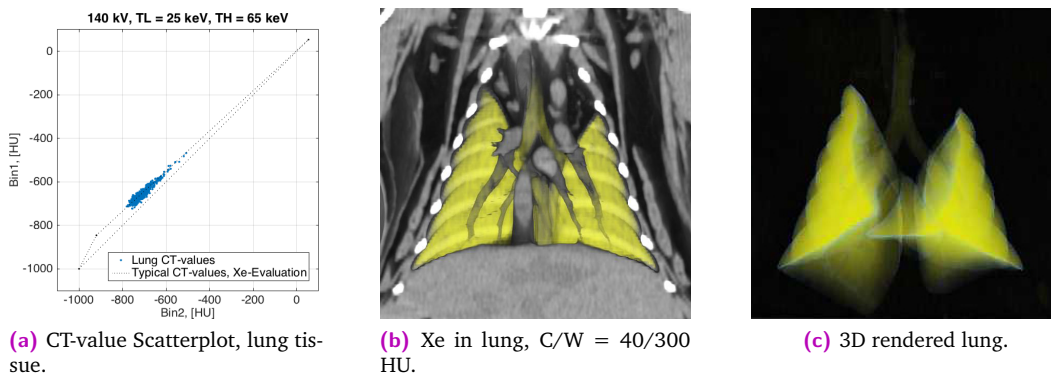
Xenon imaging of PCD-CT data.
